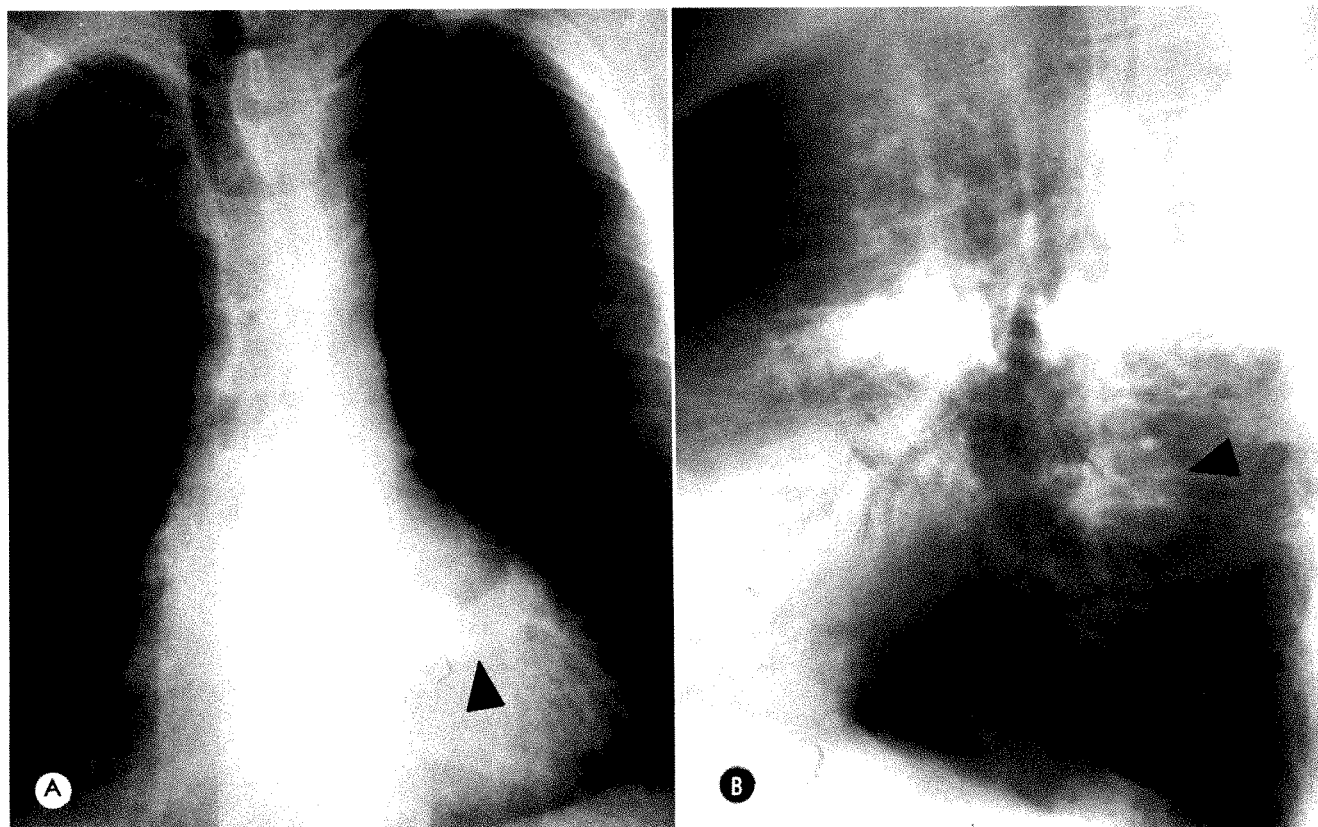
Case 1. Chest radiographs showing curvilinear density posterior to left heart (A) with its anterior border adjacent to left atrium (B). Thyroid enlargement accounts for left paratracheal mass.
